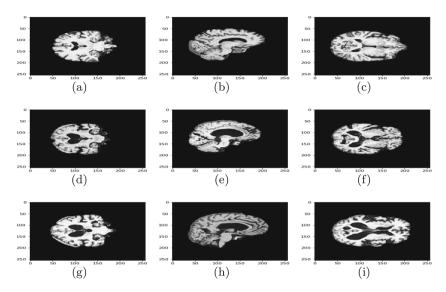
Skull-stripped MRI slices presenting different AD stages. (a)–(c) CN; (d)–(f) MCI; (g)–(i) AD.
